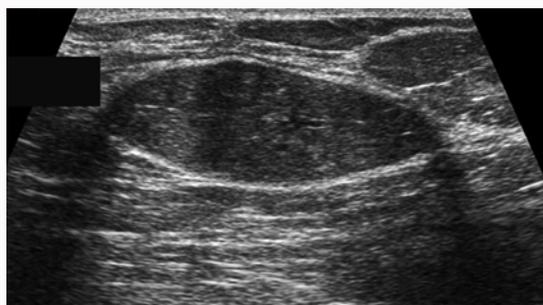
Transverse ultrasound shows well-circumscribed hypochoic oval mass with parallel orientation.
